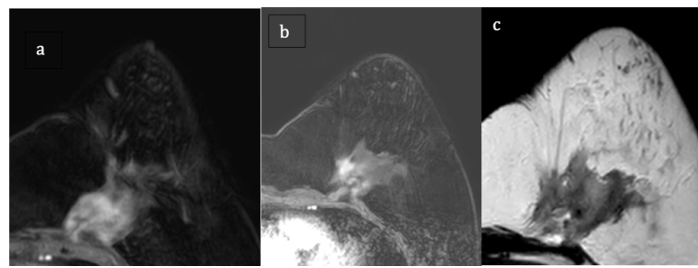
Axial MRI examination show a deep irregular mass with irregular margins hypointense in T2 [c] characterized by heterogenous enhancing on postcontrast T1 with fat saturation [a,b]
